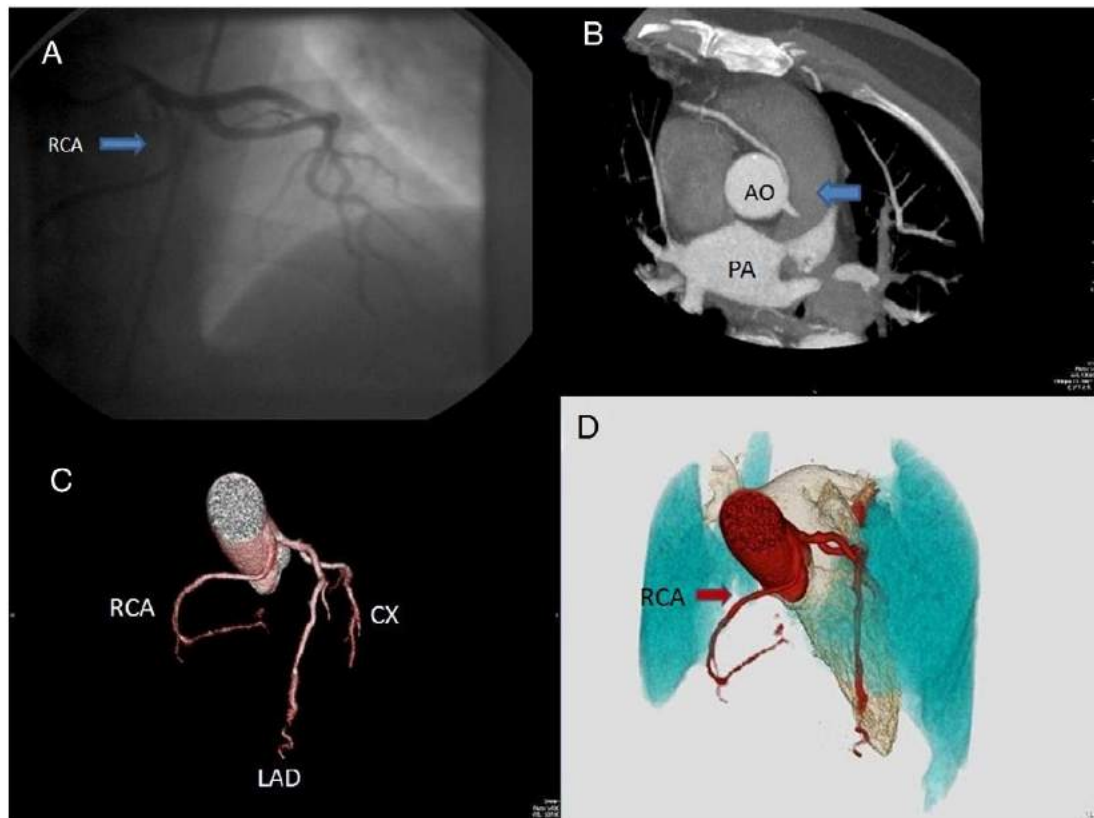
A: Selective angiogram of the left coronary system in the right anterior oblique projection. The arrow shows right coronary artery (RCA) originating from left coronary sinus. B: Maximum intensity projection of top of heart by multidetector computed tomography. The arrow is showing both RCA and left coronary artery originating from left coronary sinus. RCA courses between pulmonary artery (PA) and aorta (AO). C: 3D-volume rendered image of multidetector computed tomography showing anomalous right coronary artery (RCA) (pulmonary artery is not demonstrated). D: 3D volume rendered image of multidetector computed tomography. The arrow is showing the RCA with an interarterial course. (pulmonary artery is not demonstrated).
